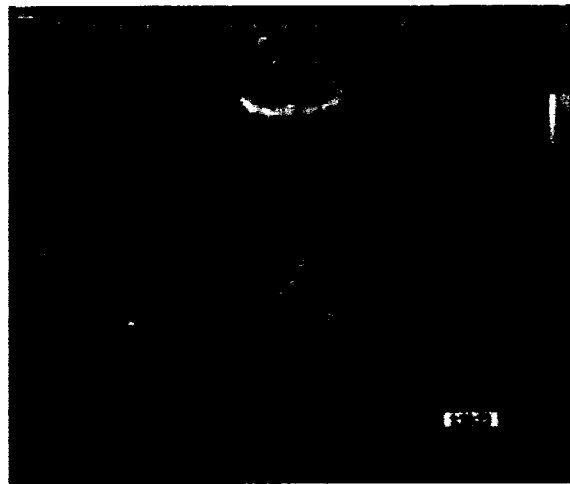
Color Doppler image of some of the branches of middle cerebral artery (MCA) of a patient who underwent neurosurgery to remove a brain tumor. The Doppler signal is superimposed on the gray-scale B-mode image.
